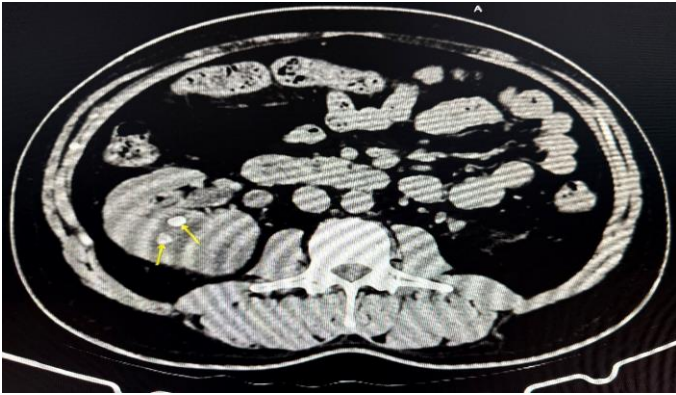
Axial cut of CT KUB Plain showing moderate to gross right upper moiety hydronephrosis with hyperdense calculi in the upper moiety of right kidney measuring 7.7mm and 6.4mm respectively.
